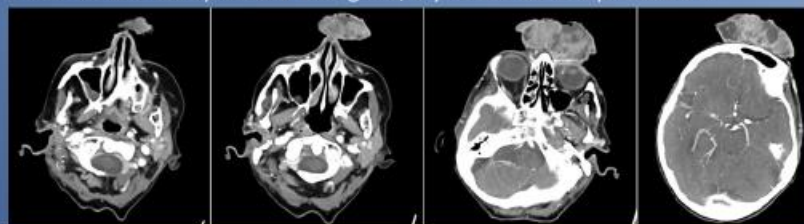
CT slices showing the position and extent of the melanoma.
